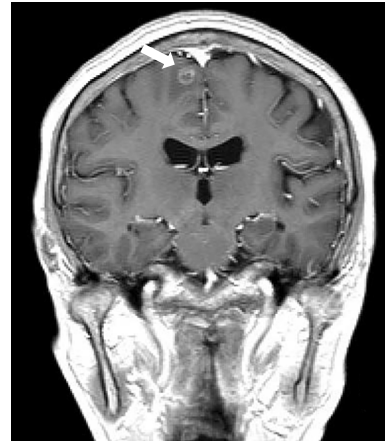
Brain magnetic resonance imaging showing a 1-cm right-sided frontal lobe tumor (arrow).
